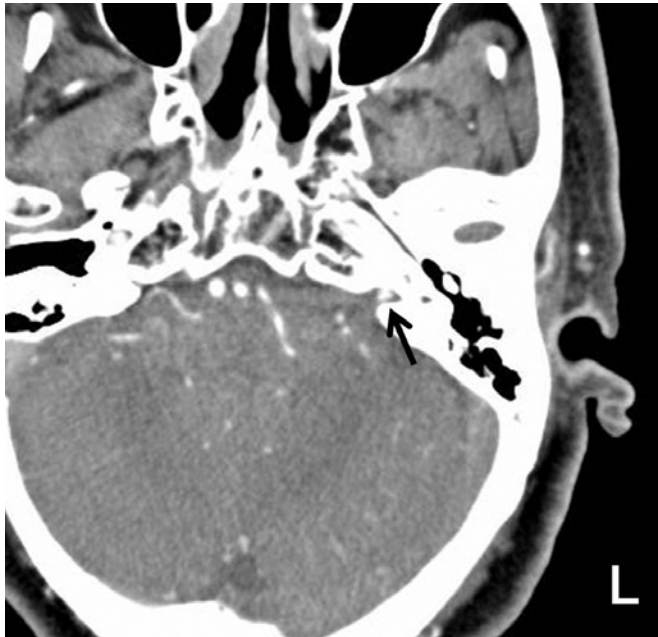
Contrast-enhanced CT showing an aneurysmal dilatation in the left internal auditory meatus (black arrow)
